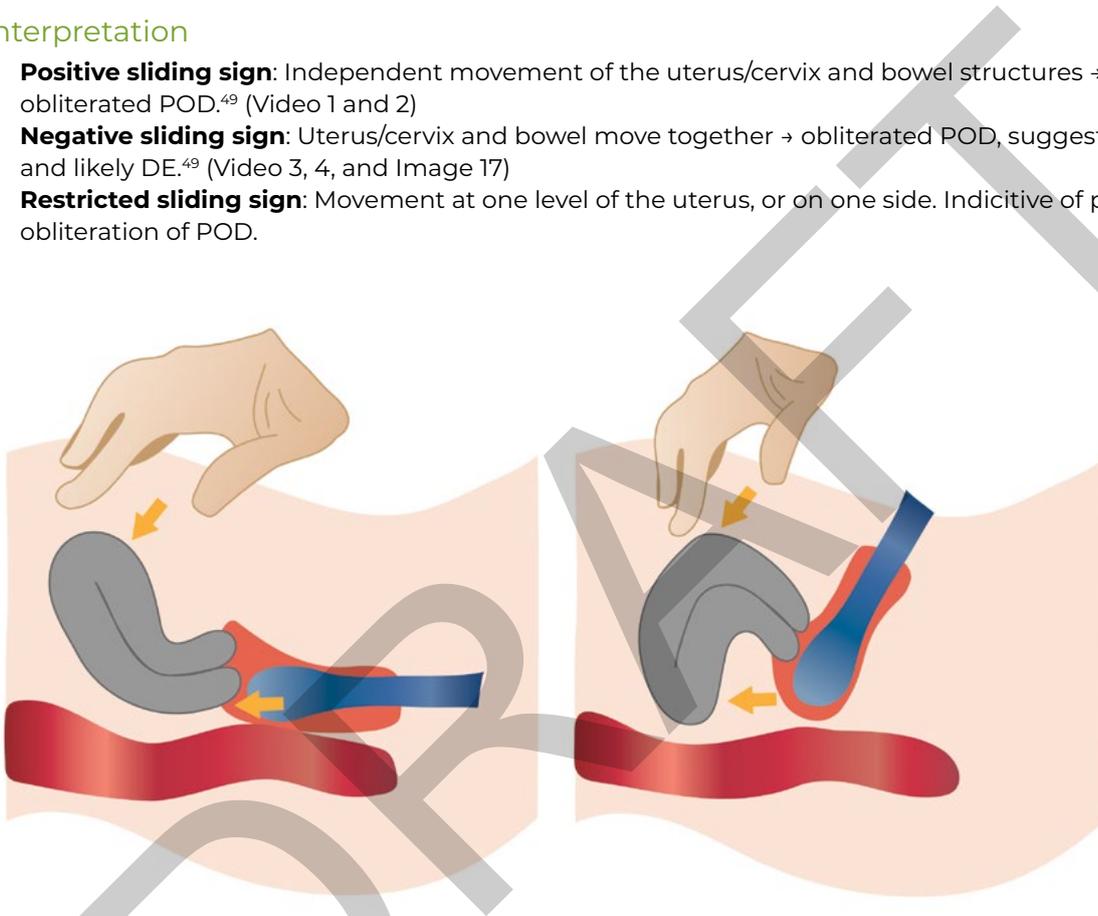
Demonstration of the sliding sign on transvaginal ultrasound, assessing the movement between the posterior uterine serosa and the anterior rectum to determine POD obliteration.
